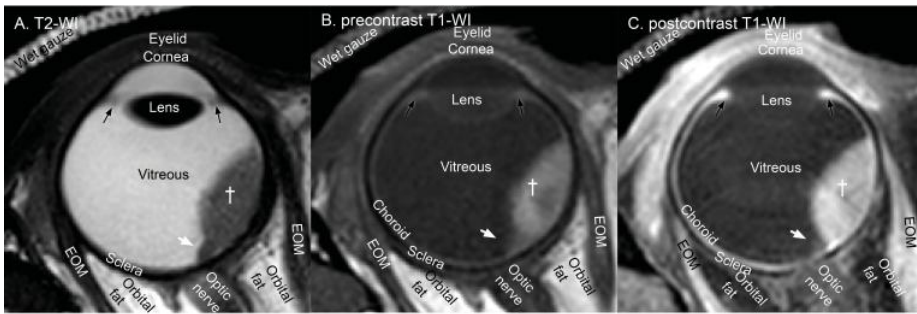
Transversal anatomical MR-images of a patient with a uveal melanoma (dagger) and associated retinal detachment (white arrow). (A) T2-weighted imaging showing a hypointense tumour. (B) T1-weighted imaging before contrast agent without fat suppression and (C) T1-weighted imaging after contrast agent administration with fat suppression showing an hyperintense tumour which is enhancing. Note that the choroid, extra ocular muscles (EOM), ciliary body (black arrow) and eyelid which enhances.
